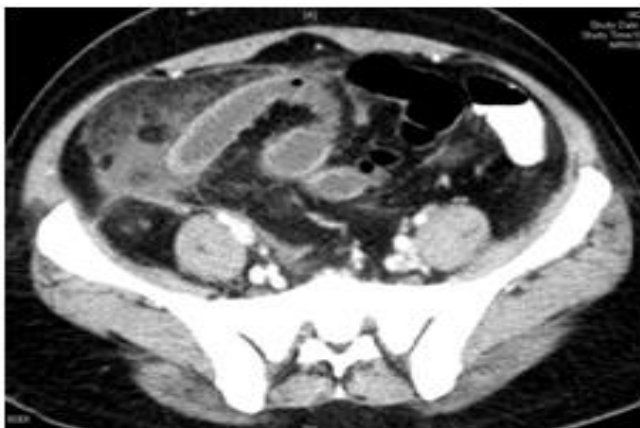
CT Abdomen showed significant intraperitoneal fat streakiness with minimal free fluid collections with extraluminal free air pockets near the mid descending colon.
